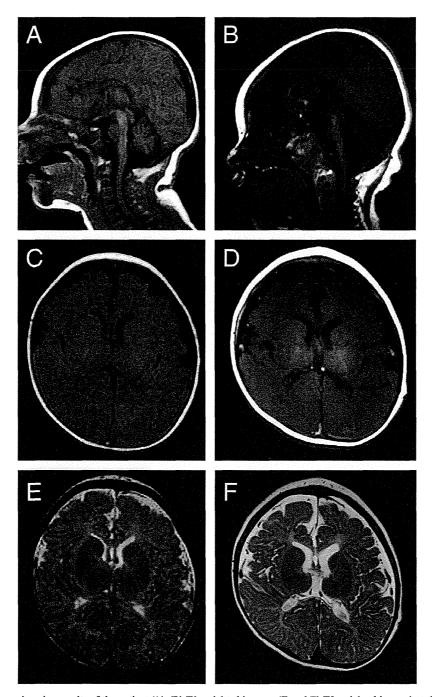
Magnetic resonance imaging results of the patient ((A-D) T1-weighted images, (E and F) T2-weighted images) at the age of 2 months (A, C and E) and 1 year (B, D and F). Cerebral myelination did not proceed between these two periods, thus resulting in a marked hypomyelination at the age of 1 year. Note the diffuse brain atrophy at this latter period, which is most marked at the brainstem and cerebellum.
